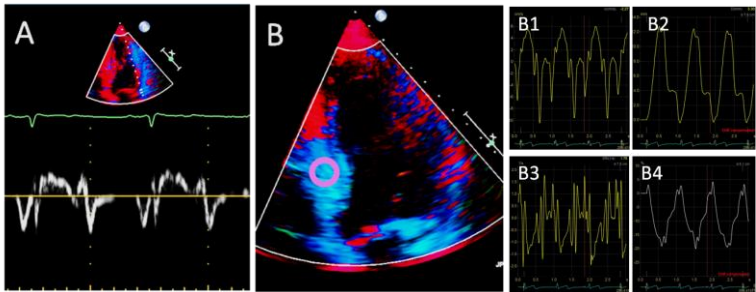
A: Myocardial velocities derived from Doppler tissue imaging (TDI) spectral pulse wave (PW) Doppler. B: DTI colour; B1 velocity curve; B2 displacement curve; B3 strain-rate curve; B4 strain curve.
